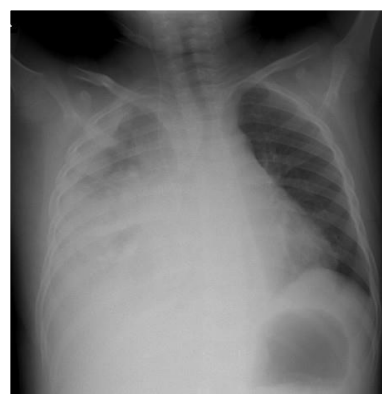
Second Chest X-ray
